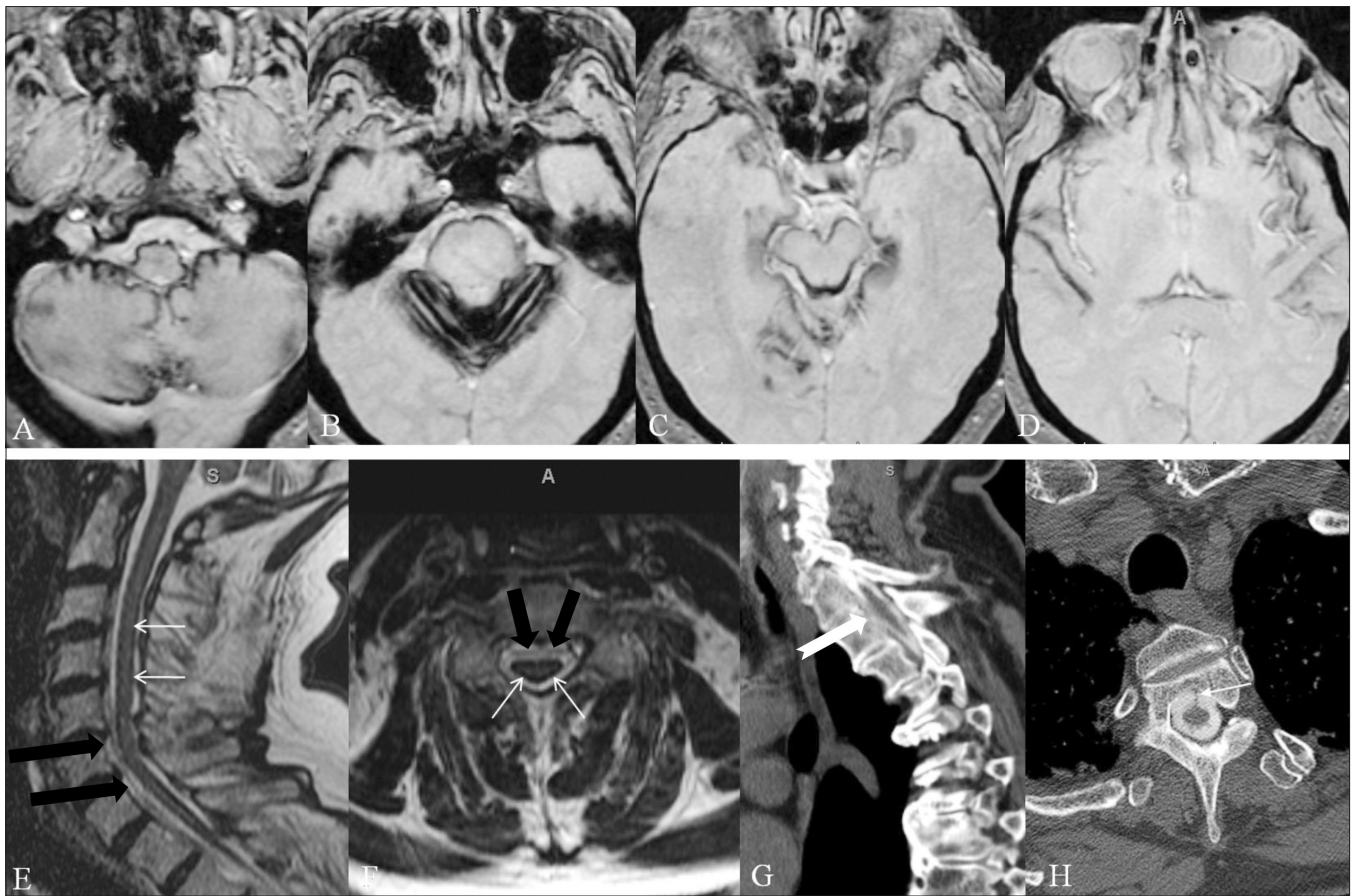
(A-H): Axial gradient-echo MRIs from inferior to superior (A-D) shows superficial siderosis around the cerebellar folia and brainstem. Sagittal T2W (E) and axial T2W (F) spine MRIs show a ventral fluid collection extending from C₂-D₉ (thick black arrows). Also noted is a thin rim of T2 hypointensity around the surface of the cord (thin white arrows) due to superficial siderosis. Sagittal immediate dynamic CT myelogram (G) shows leakage of contrast into the ventral collection at T₁-T₂ level (notched white arrow). Axial immediate dynamic CT myelogram (H) shows a lucent line in the ventral fluid collection, which may represent a fibrous band (thin white arrow). At surgery, a connection between the ventral collection and the main dural cavity was identified on the right at the T₁-T₂ level. Also identified were multiple abnormal blood vessels near the right nerve root sleeve, one of which was an acute bleeder and was the potential source of bleeding responsible for the superficial siderosis
